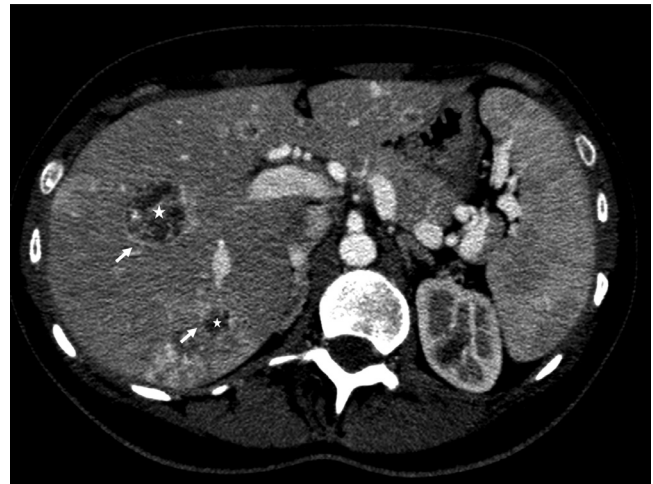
Hepatic hemangioma-like metastasis. Axial contrast-enhanced CT image, venous-phase, shows multiple hypervascular lesions in both hepatic lobes with hemangioma-like appearance with peripheral vascularity (arrow) and central vascular spaces (star).
